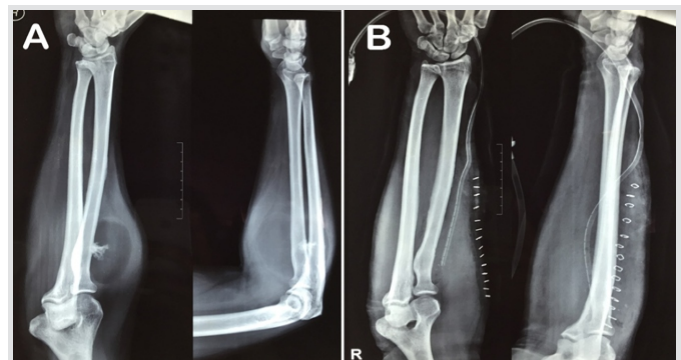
Plain radiographs of the forearm in anteroposterior and lateral views. (a) Pre-operative image showing soft tissue shadow of the tumor arising from proximal radius (b) post-operative image showing complete excision of the mass.
